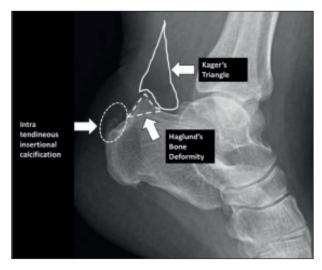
The X-Ray in lateral-lateral projection shows a typical picture of Haglund S. with hypertrophy of the postero-superior portion of the calcaneum, the triangle of kager not perfectly diaphanous and calcific insertional tendonopathy
